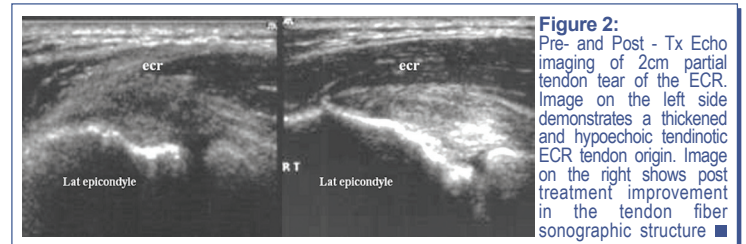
Pre- and Post - Tx Echo imaging of 2cm partial tendon tear of the ECR. Image on the left side demonstrates a thickened and hypoechoic tendinotic ECR tendon origin. Image on the right shows post treatment improvement in the tendon fiber sonographic structure ■
